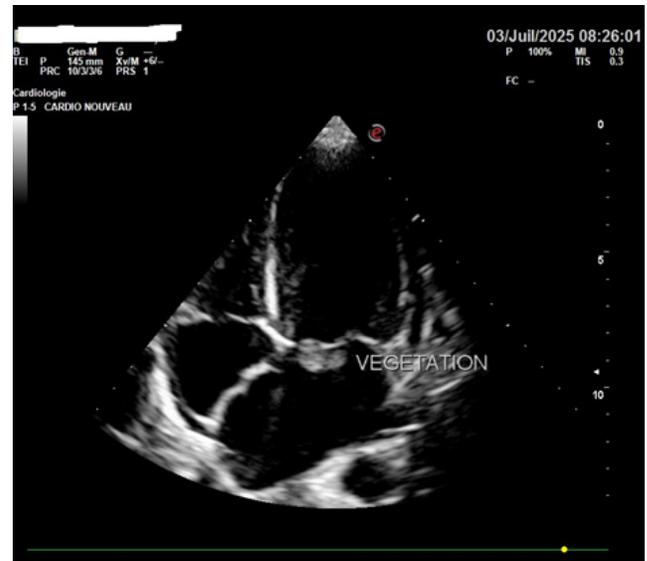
Four-chamber echocardiogram showing the presence of a 19 x 10 mm vegetation on the atrial side of the large mitral valve.
